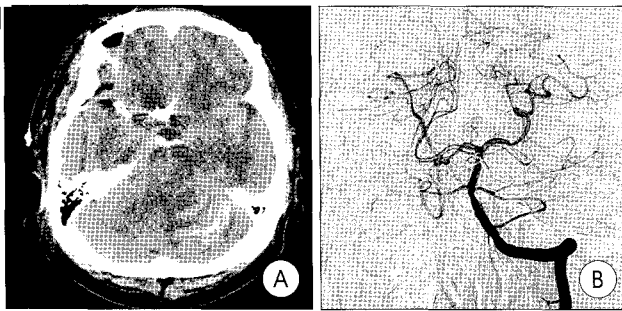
A : Nonenhanced computed tomography scan of postoperative third day showing a left cerebellar hemispheric and vermian hemorrhage. B : On left vertebral artery angiography, there is no other vascular lesion at the infratentorial region.
